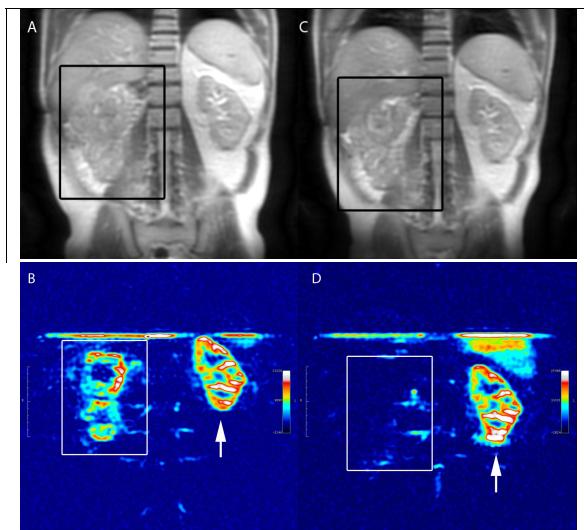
Coronal T2-weighted (A) and perfusion (B) images prior to therapy in a patient with history of right nephrectomy for RCC and local recurrence in the nephrectomy bed (box). ASL MRI shows high levels of perfusion within the mass, similar to those of the renal cortex in the left kidney (arrow). Coronal T2-weighted (C) and perfusion (D) images of the same patient obtained 1 week after initiation of antiangiogenic therapy with sorafenib and bevacizumab show minimal decrease in size of the lesion but marked decrease in the tumor vascularity.
